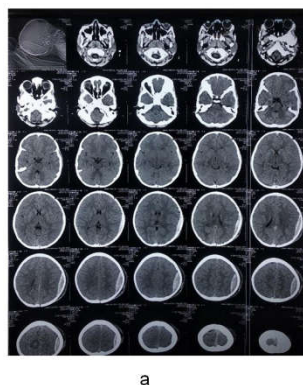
Figure iii (Patient 3): Hematoma size did not increase. Patient was treated conservatively. (a) CT head on admission (b) CT head on 3rd post admission day.
